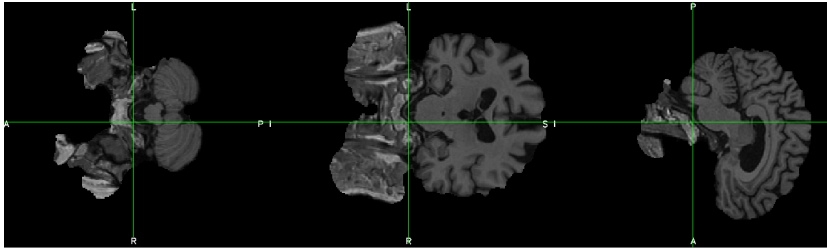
MRI scan of a MCI patient after applying BET.
